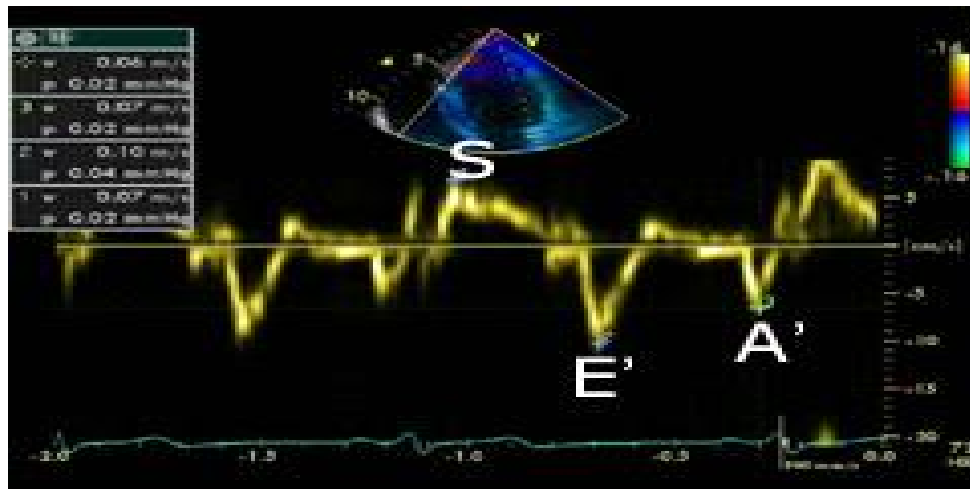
Estimation of S, E', and A' with tissue doppler imaging
